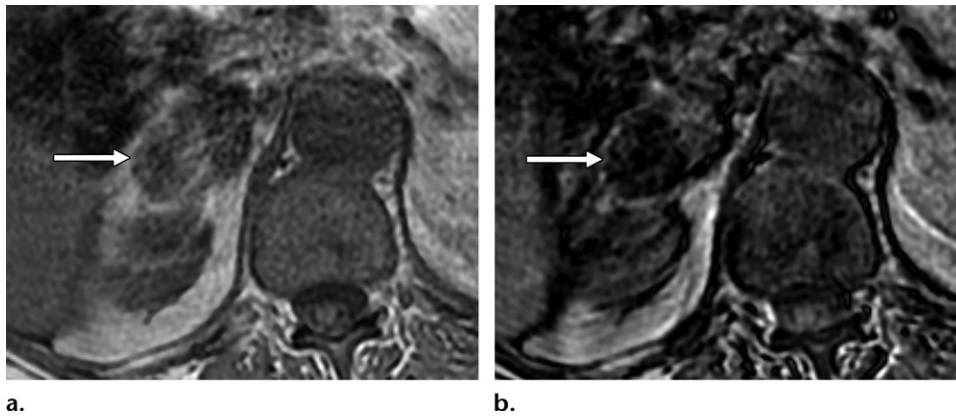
Chemical shift MR images in a patient with known lung malignancy, chronic lung disease (accounting for respiratory artifact, depicted here), and known adrenal adenoma show an enlarging heterogeneous right adrenal mass. Axial in-phase (a) and out-of-phase (b) chemical shift MR images show heterogeneous signal loss. Signal loss is depicted in the lateral component of the lesion (arrow), although no convincing loss is depicted in the medial component, when allowing for signal intensity loss elsewhere in the image. These findings were due to a new metastasis in the medial portion of the gland. The signal loss is within the original adrenal adenoma. The overall imaging appearance reflects a collision tumor, a diagnosis that should be considered in lesions with heterogeneous signal loss, primarily in patients with known malignancy elsewhere.
